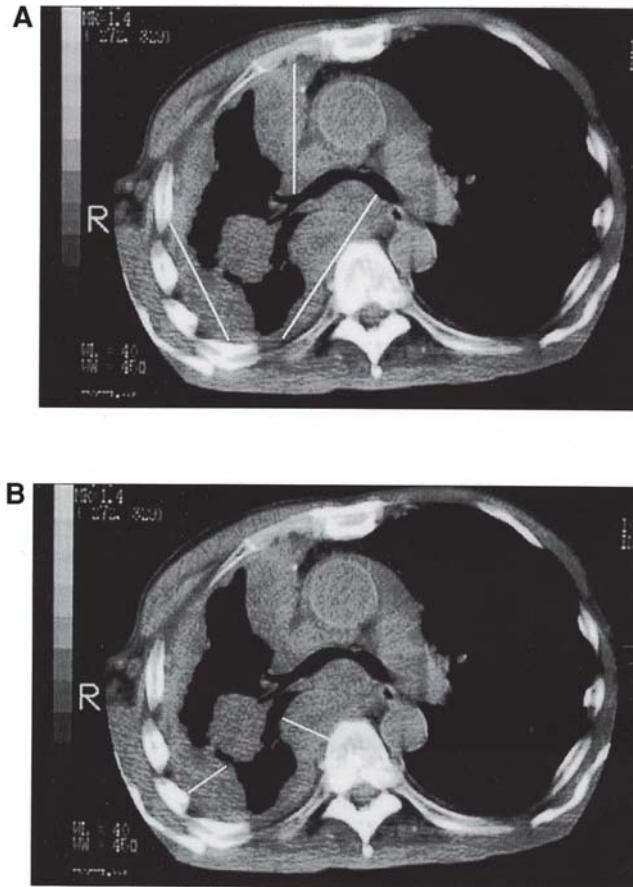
Example of measurement of a single computed tomography scan slice. (A) Lines represent possible interpretations of 'longest tumour diameter' according to current RECIST criteria. (B) Lines represent suggested measurement sites perpendicular to fixed structures, chest wall and vertebral column, according to Modified RECIST criteria.
